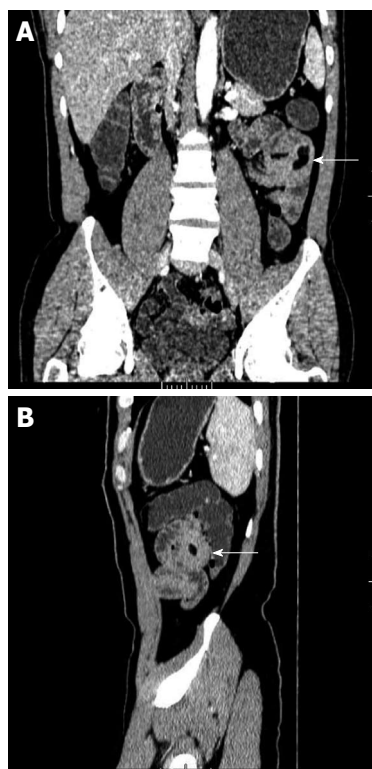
Lipoma of the jejunum in a 56-year-old man who presented with a 3-year history of hematochezia. A: Image (Coronal MPR) of contrast-enhanced CT scan shows a homogeneous fat-tissue density mass in jejunal smooth muscle (white arrow); B: Image (Sagittal MPR) shows obviously thickened intestinal wall (white arrow). MPR: Multiplanar reconstruction.
